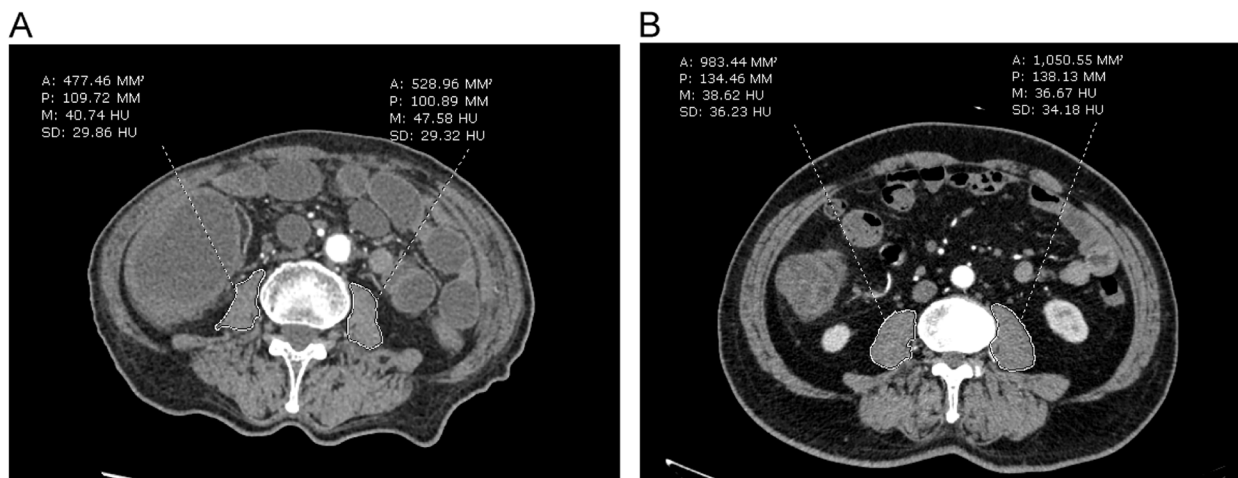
Measurement at the inferior end-plate level of the L3 vertebral body. Psoas (ROI) and the generated results were indicated by the dashed lines. A CT of a patient with sarcopenia; B CT of a patient without sarcopenia
